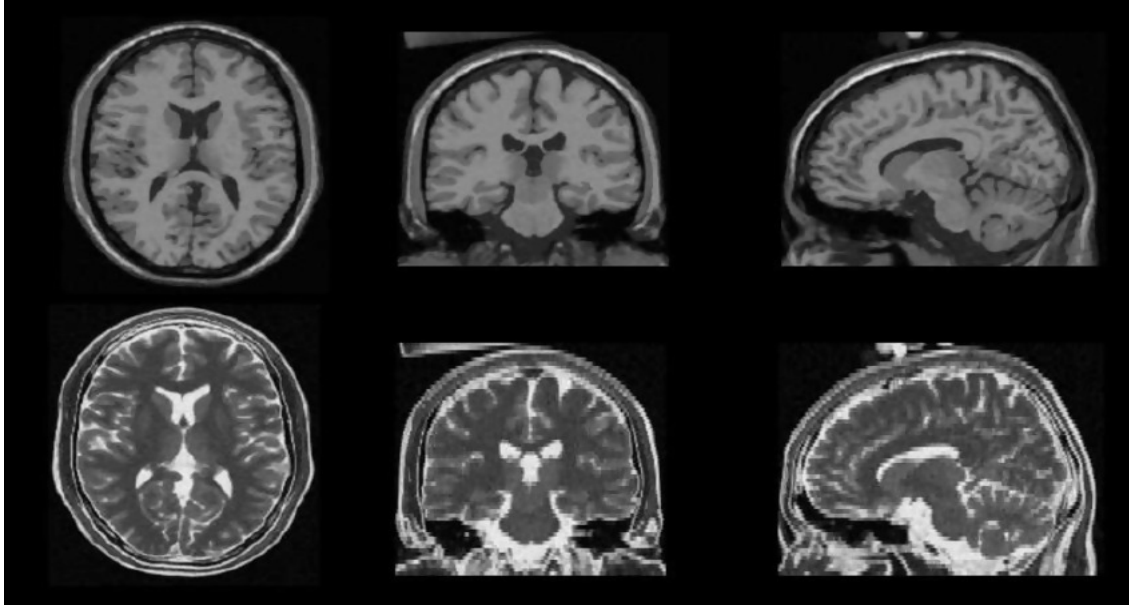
Example of MR data [61]. First row: high resolution T1-weighted image (1 mm slice thickness); second row: low resolution T2-weighted image (3 mm slice thickness).
